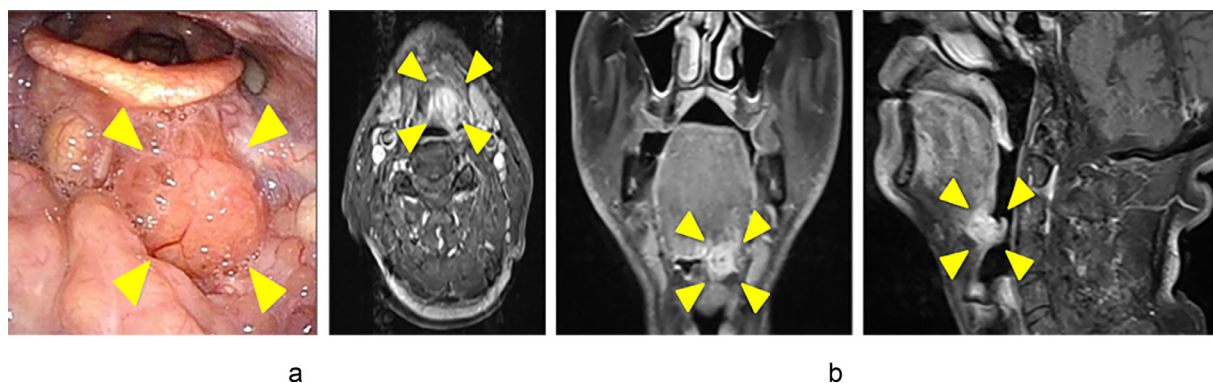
Findings at the time of initial visit to our hospital. (a) Nasopharyngoscopy: tumor, 21 mm in diameter, extending from the tongue base to the epiglottis valley (yellow arrow). (b) Contrast-enhanced magnetic resonance imaging: contrast nodule 21 mm long on the left side of the tongue base (yellow arrow).
